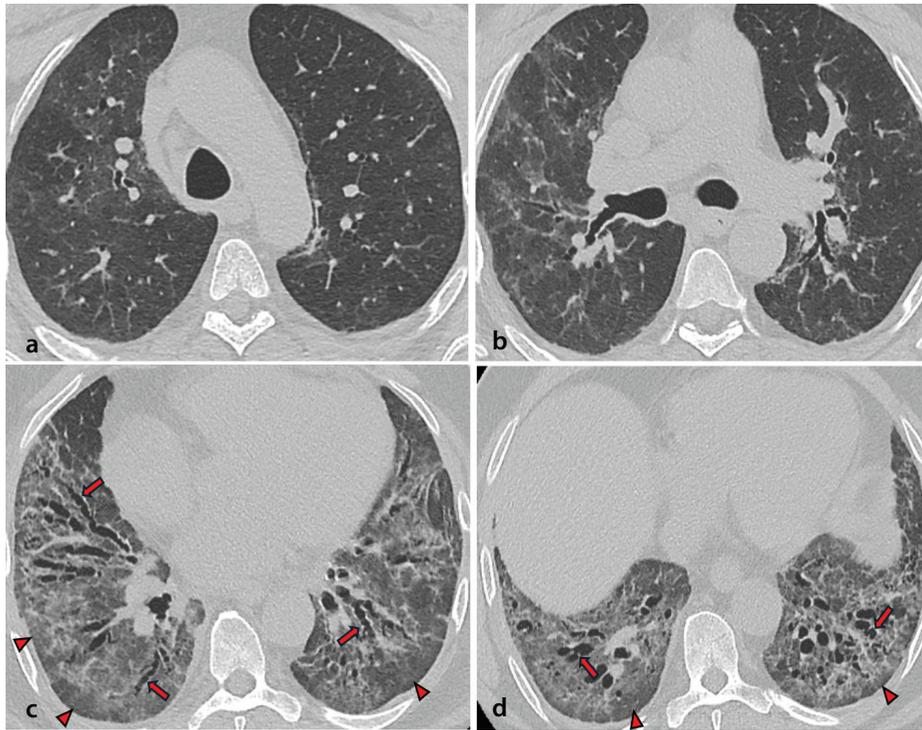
Non-specific interstitial pneumonia pattern on chest computed tomography (CT). Axial CT images (a–d) demonstrate bilateral ground-glass opacities and fine reticulation with lower-lobe predominance, accompanied by traction bronchiectasis (arrows) and areas of subpleural sparing (arrowheads). Findings are shown in a patient with systemic sclerosis–associated interstitial lung disease.
